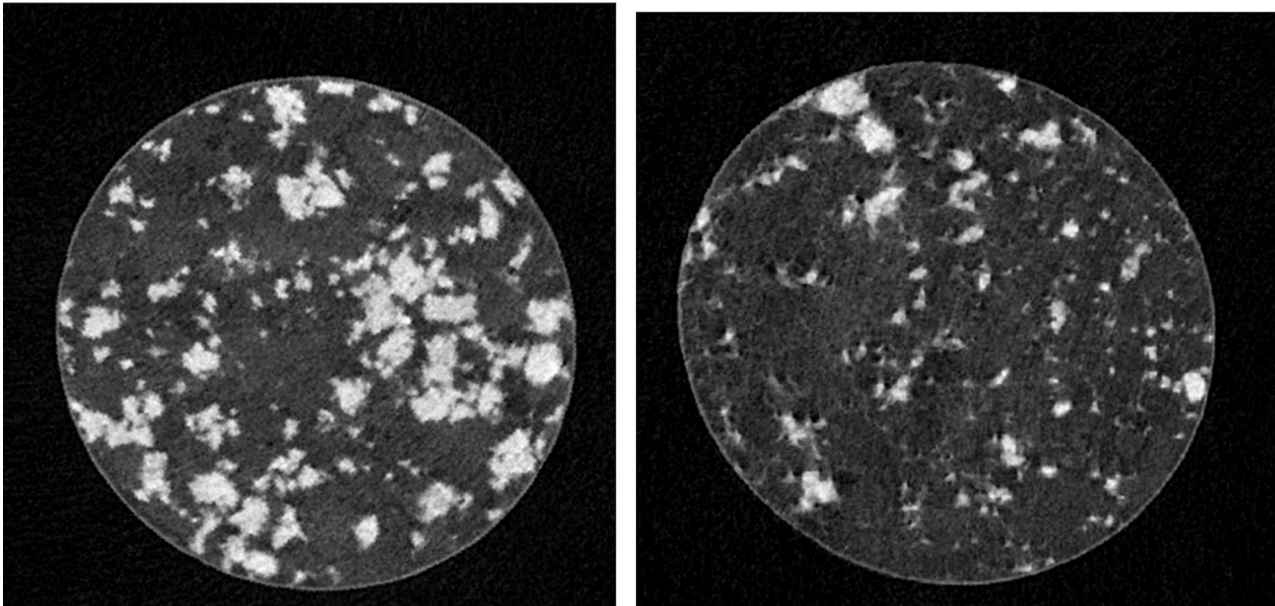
μ CT virtual slit images of Slenyto® film-coated matrix mini-tablets (3 mm) with 1 mg (left) and 5 mg melatonin (right) showing both taste-masking and coloring by thin film-coatings, but SR characteristics due to the Eudragit® RS matrix former in the tablet core. Areas with bright pixels encode locations of calciumhydrogenphosphate dihydrate particles.
